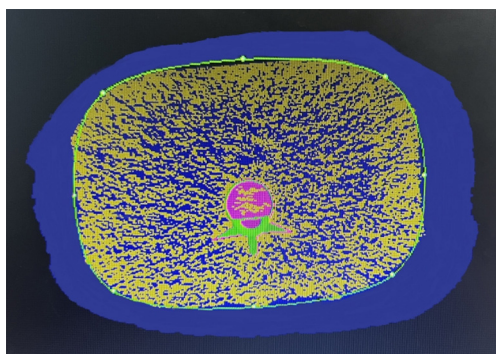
QCT measures the abdominal fat at the central level of the L2. The blue part outside the green aperture is the total abdominal fat. QCT, quantitative computed tomography.
